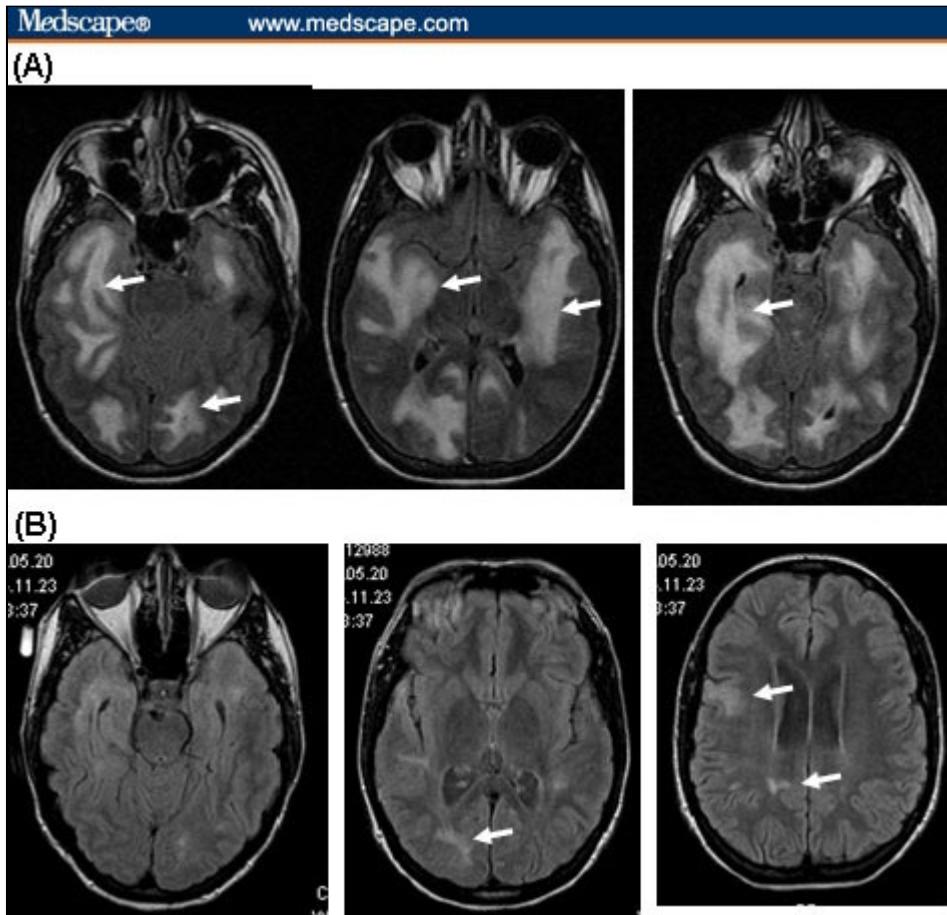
MRI images depicting acute disseminated encephalomyelitis. (A) FLAIR images from time of acute presentation demonstrate large, confluent areas of T2 prolongation (arrows). (B) FLAIR imaging findings almost completely normalized after a single course of intravenous (IV) steroids and IV immunoglobulin, leaving only a few, small areas of T2 prolongation (arrows).
